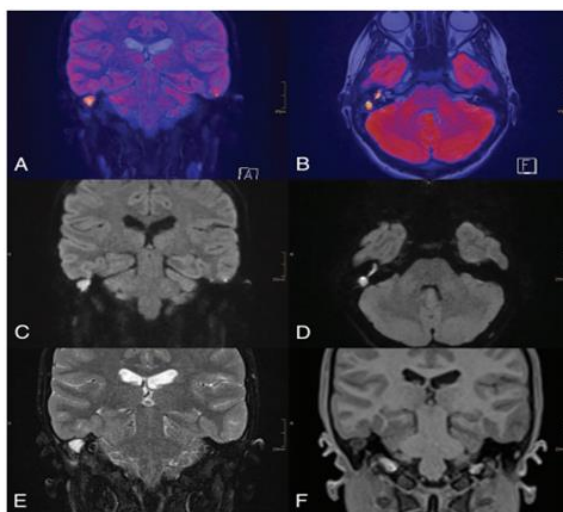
Description of cholesteatoma on MRI
